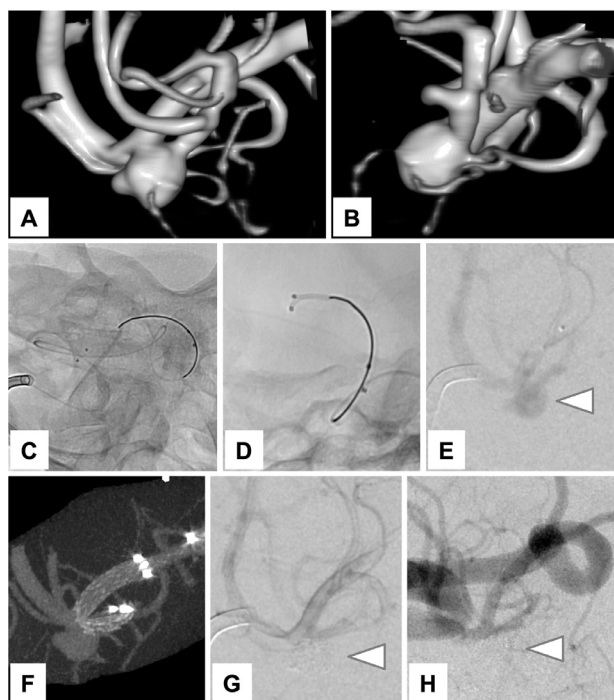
Preoperative 3D-digital subtraction angiography shows the right middle cerebral artery aneurysm (A,B). Navigating 2 microcatheters to the right middle cerebral artery (M1) (C,D). Right middle cerebral artery angiogram injected from the microcatheter placed at M1 shows the right middle cerebral artery aneurysm (E). Cone beam CT shows the Neuroform Atlas stent covering the aneurysm neck (F). Post-treatment angiogram shows complete obliteration of aneurysm (G). Angiogram 6 months after treatment shows no recurrence of aneurysm (H).
